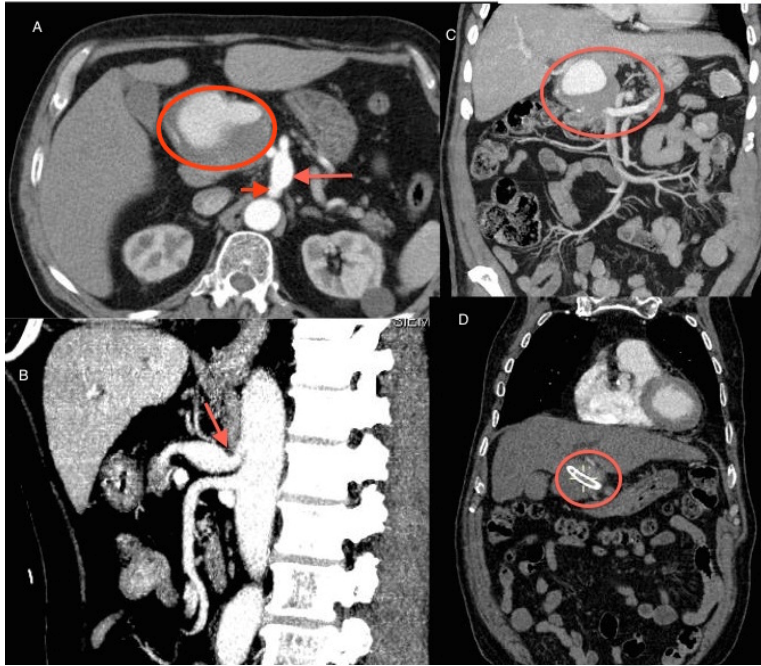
Abdominal-pelvic CT with intravenous contrast in the arterial phase. A. Axial plane image. Short arrow: stenosis at the origin of the celiac trunk; long arrow: post-stenosis dilatation; and circle: aneurysm of the hepatic artery. B. Sagittal plane image. Arrow: imprint of the median arcuate ligament at the origin of the celiac trunk. C. Coronal plane image. Circle: large aneurysmal dilatation of the hepatic artery. D. Coronal plane image. Circle: aneurysm of the hepatic artery treated by stent.
